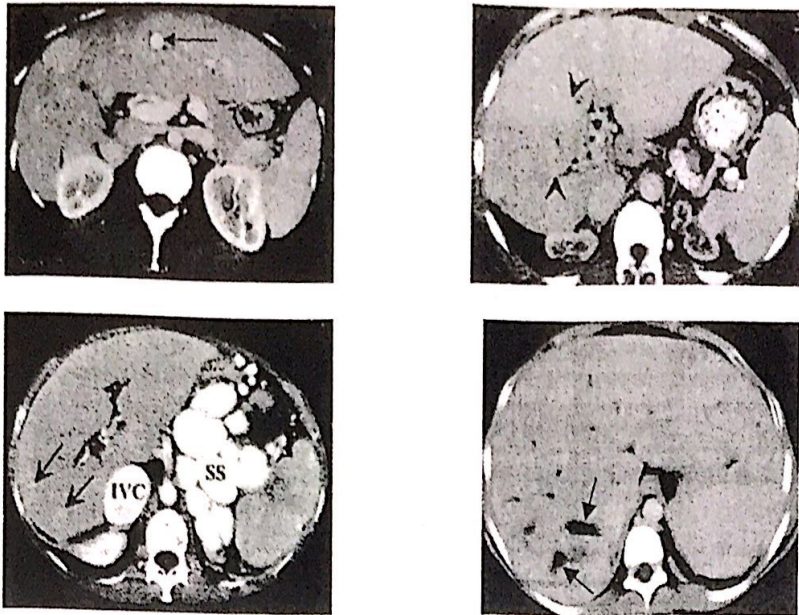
CT sample images for Hepatic Adenoma Liver.
